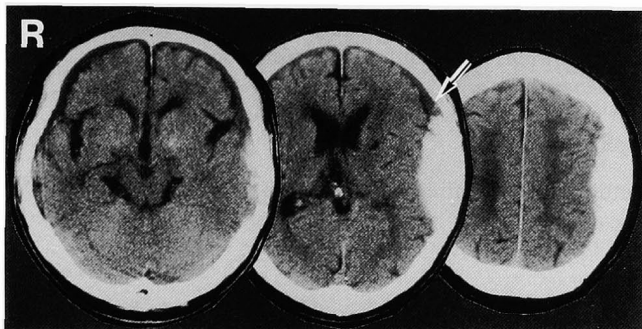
Computed tomography scans 24 hours after the accident showing no remarkable change. Note the low density area above the hematoma with a niveau (arrow).
